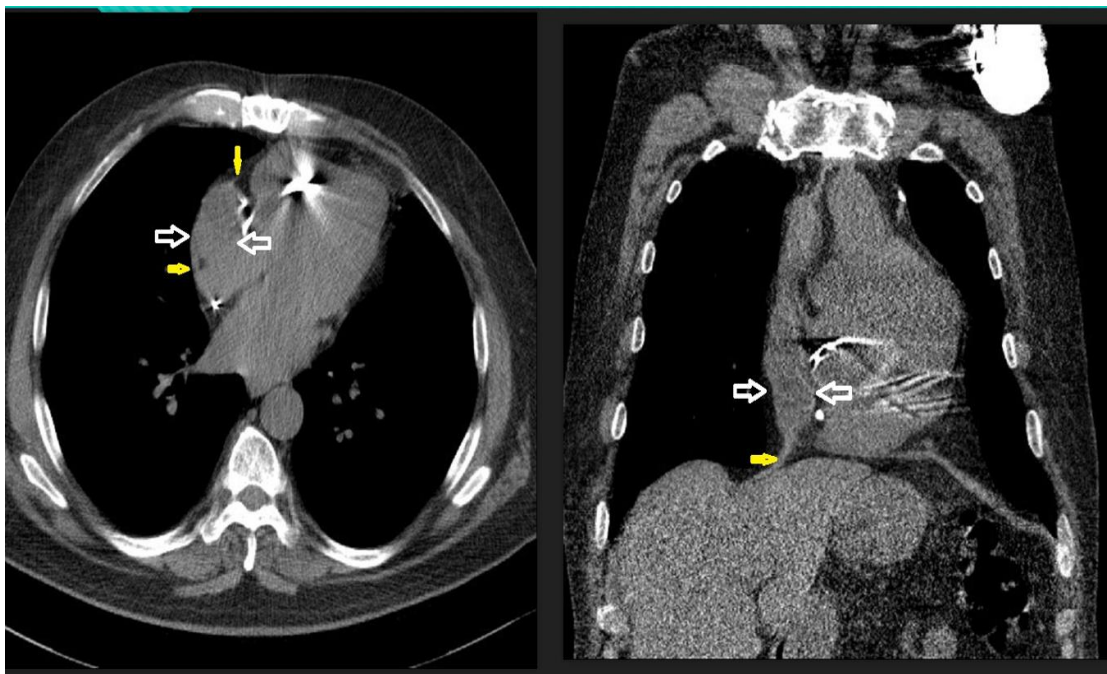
Left: The axial non-contrast thorax computed tomography shows a cystic lesion (the white arrow) at the right lateral aspect of the right atrium and adjacent to the pericardium (the yellow arrow).
